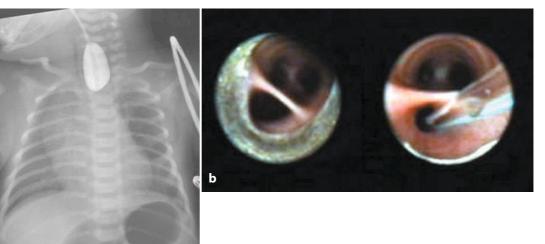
Esophageal atresia. Chest radiograph showing esophageal atresia through the fistula (a). TEF with an open pouch (b, left) and placement of a catheter (b, right)
